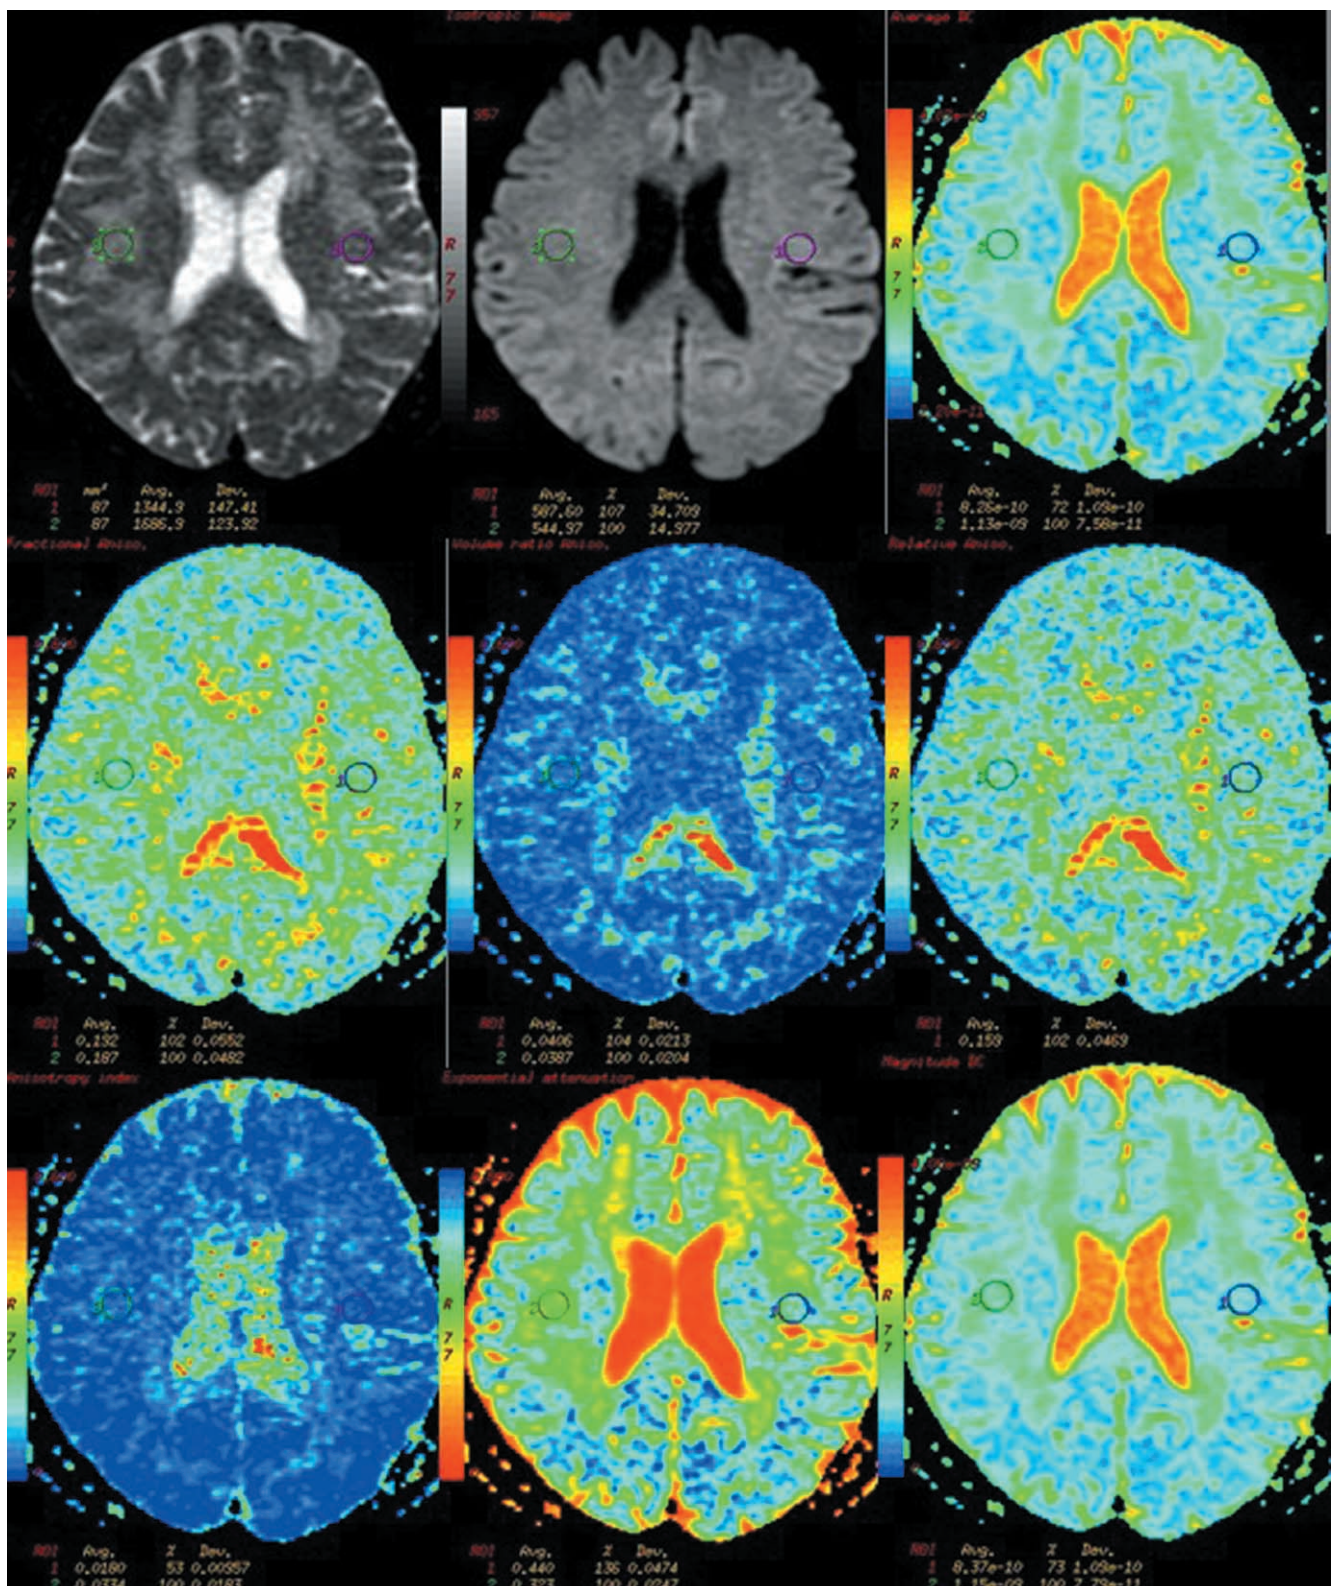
The MR images of a 60-year-old woman, who suffered from hypertension and cognitive dysfunction, showed marked microangiopathy at the deep white matter. The diffusion tensor images were processed and they were used to measure the values of several indices at the contra-lateral normal area (left circle) and the area of microangiopathy (right circle).  $B_0$  image (top line, left), Isotropic image (top line, middle), Apparent diffusion coefficient (top line, right), Fractional anisotropy (middle line, left), Volume ratios (middle line, middle), Relative anisotropy (middle line, right), Anisotropy index (bottom line, left), Exponential ADC (bottom line, middle), Magnitude diffusion coefficient (bottom line, right)
